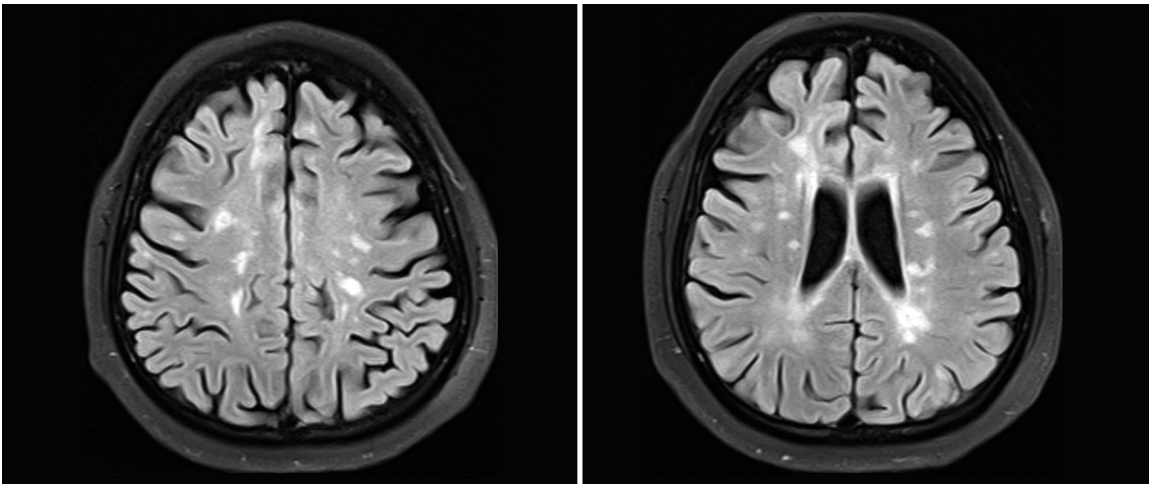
Brain magnetic resonance imaging shows discrete white matter lesions (periventricular perpendicular ovoid lesions) in a 14-year-old girl with relapsing remitting multiple sclerosis
